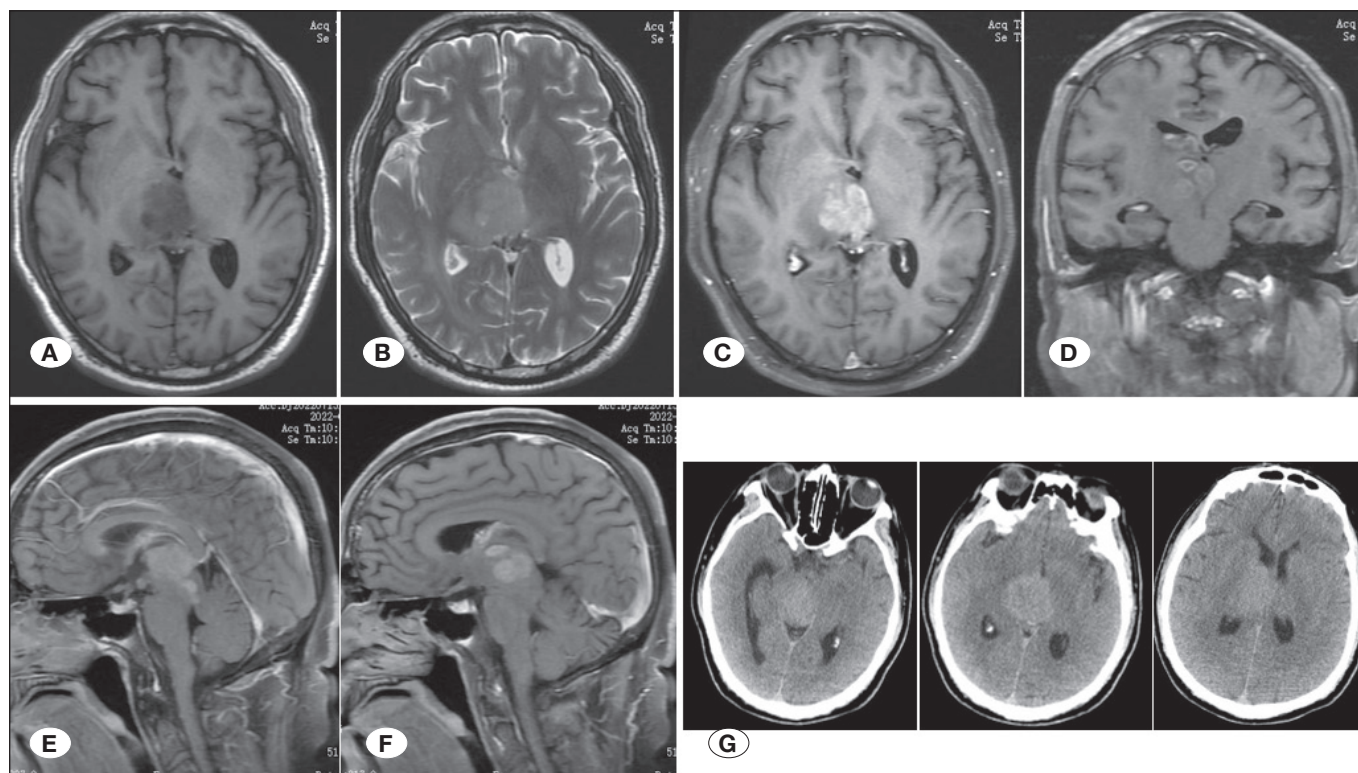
Axial A) T1W; B) T2W; C-F) contrast enhanced T1W images in axial, coronal and sagittal sections. G) CT images of the patient. Head CT was re-examined on August 12 (G), and compared with brain MRI (A-F) on July 23, the lesions of the right thalamus were significantly enlarged and compressed the brain stem.
